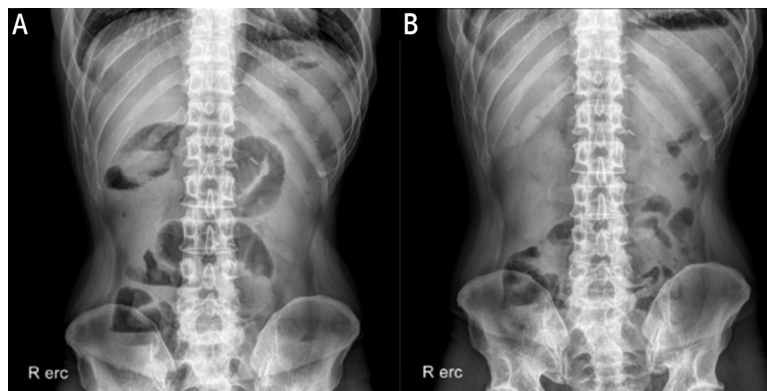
Comparison of abdominal x-ray (erect).
